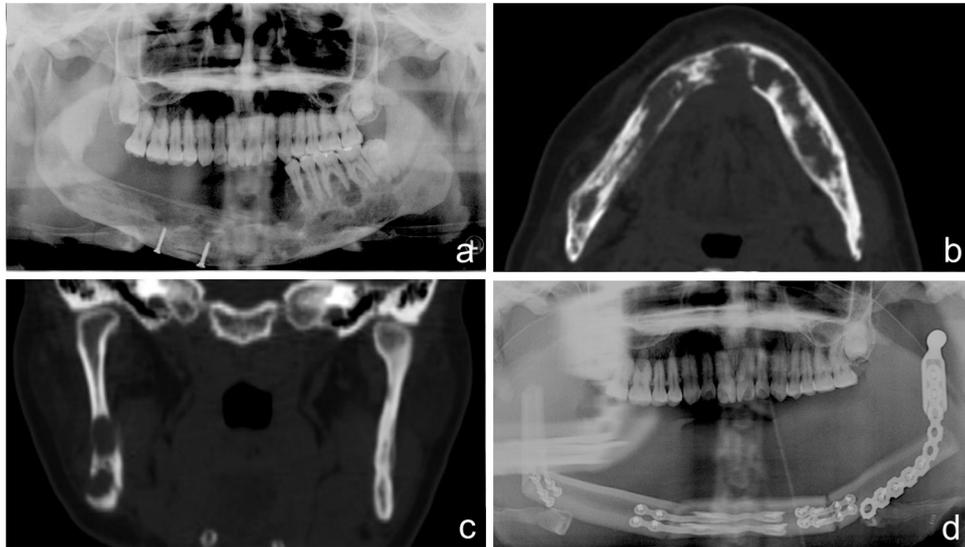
Radiological manifestations of the recurrent osteofibrous dysplasia-like adamantinoma in the mandible and the outcomes of treatment. (a) Panoramic radiograph demonstrating multifocal lytic lesions without clear margins. (b) Computed tomography showing lytic lesions involving the left mandible and the fibula flap. (c) Computed tomography demonstrating lytic lesions involving the right mandible. (d) Panoramic radiograph showing the total mandibulectomy and fibula flap reconstruction.
